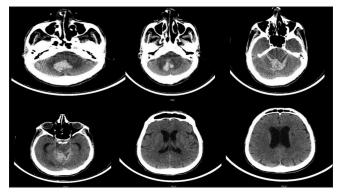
Computed tomography brain showing vermian bleed
